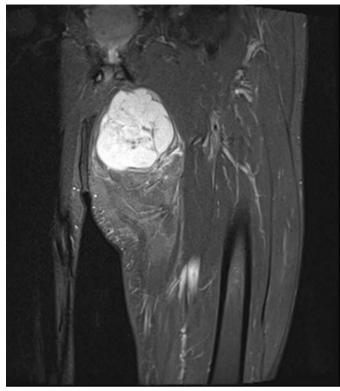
T2 MRI of the same lesion as Figure 30. Note that the fatty areas are dark and supress, while the area of dedifferentiation is bright
